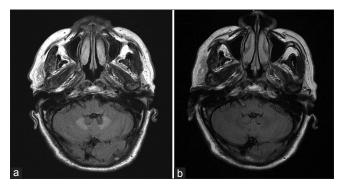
Patient 2 of metronidazole-induced encephalopathy. Hyperintense changes of bilateral dentate nuclei (a) on T2-weighted image and fluid-attenuated inversion recovery. Follow-up magnetic resonance imaging showed that complete resolution of hyperintense changes of bilateral dentate nuclei (b) after cessation of metronidazole
